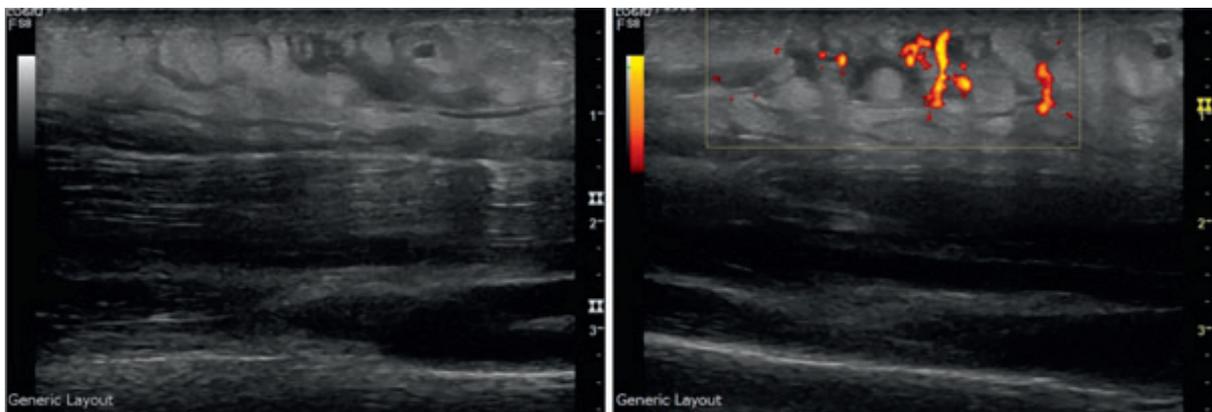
Ultrasound imaging of the left forearm showing oedema and increased vascularity of the subcutaneous tissues.
